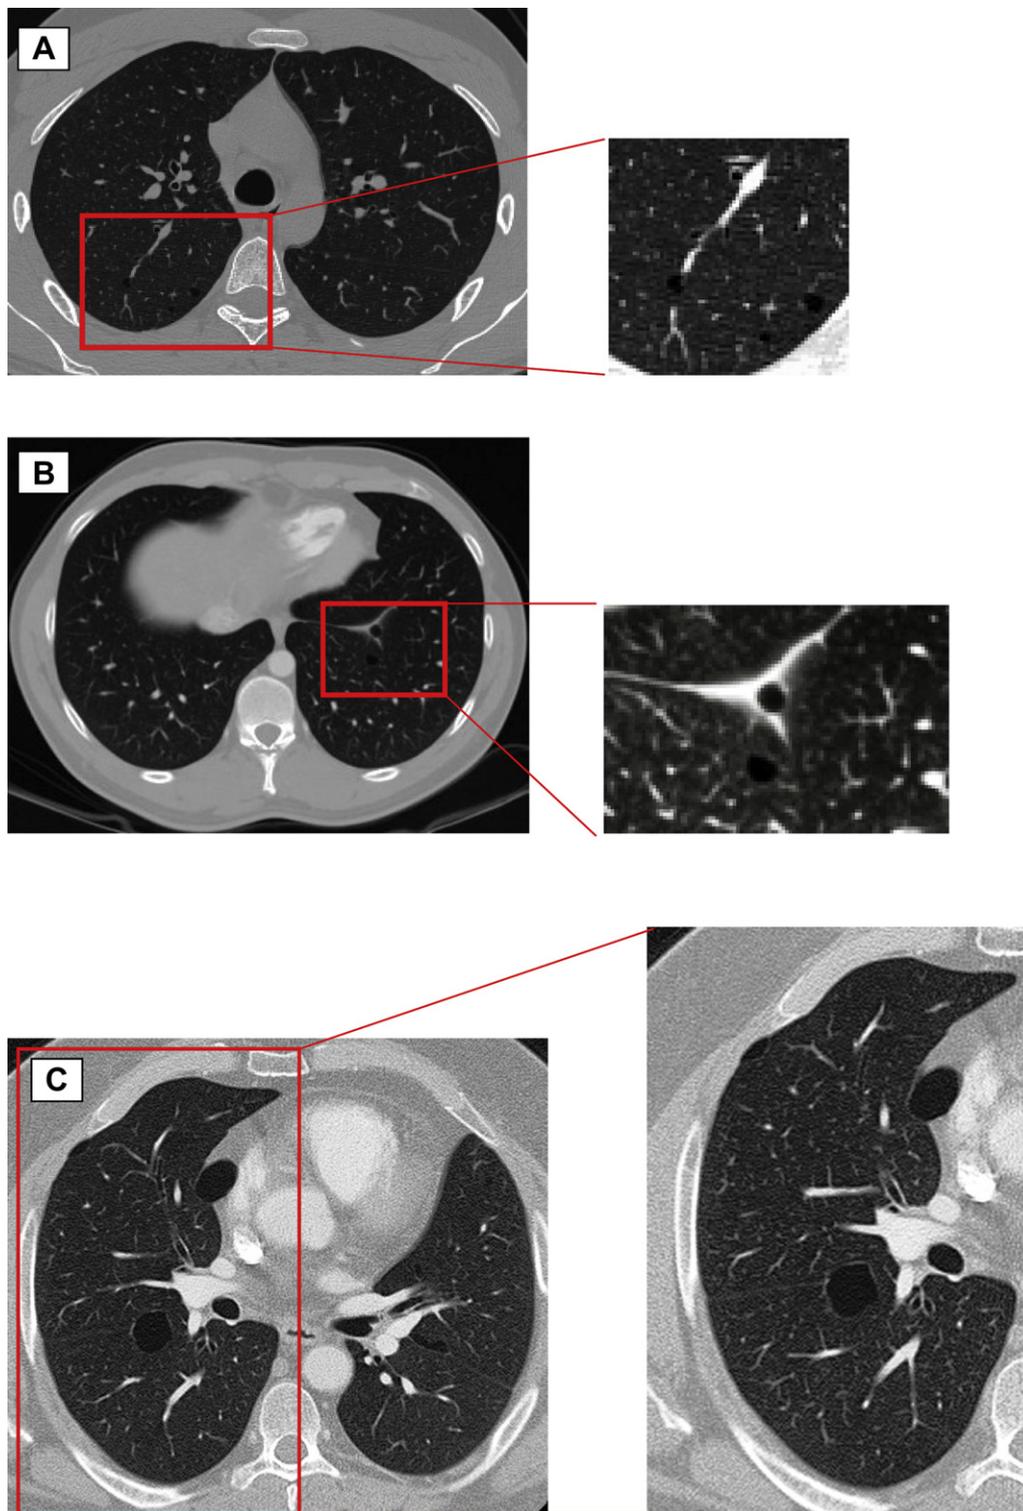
The high-resolution CT scan of two cases of BHDS. CT scan of upper lobes (A) and lower lobes (B) of the patient M/24, family #2. This case is representative of an early case of BHDS. Cysts were variably demarcated by a thin-wall and surrounded by normal parenchyma. Cysts were 4 in right lung and 7 in the left lung with diameter ranging from 3 to 8 mm. (C) CT scan of case M/52, family #1. This patient had a history of recurrent bilateral pneumothorax. The HRCT documented 3 to 6 cysts (5–31 mm in diameter) in each lung.
